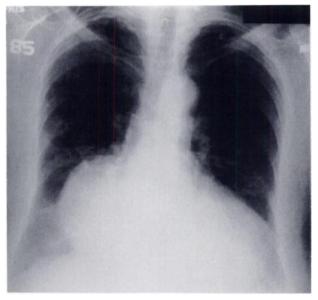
Chest x-ray showing mass in right lower lung field
